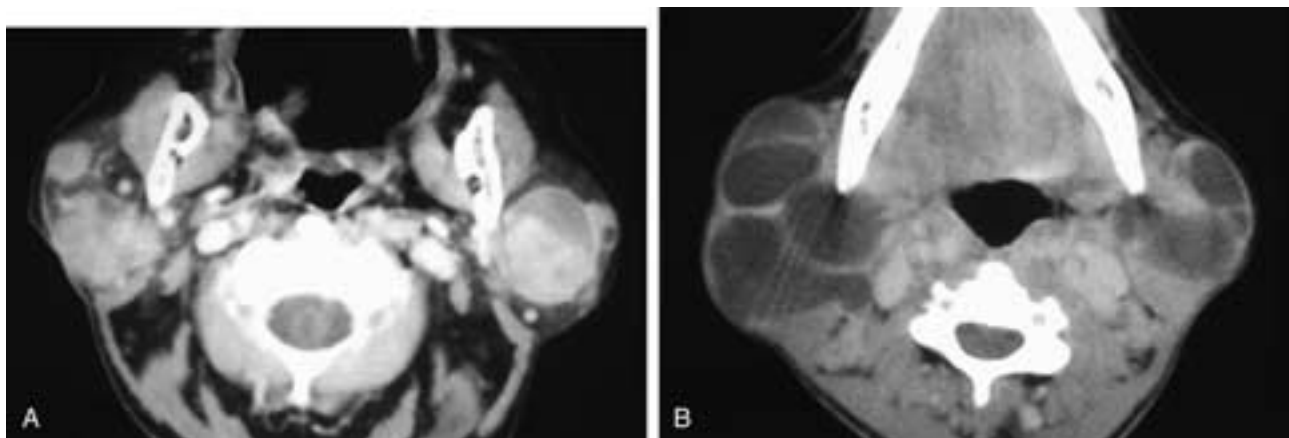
Axial contrast-enhanced CT scan (A) shows multiple bilateral parotid masses. The largest lesion on the left side is partially cystic. This patient had Warthin's tumors. In B, an axial contrast-enhanced CT scan shows multiple thinned-walled cysts in both parotid glands. No tumor nodules were seen in the cyst walls. This patient also had cervical adenopathy. These were lymphoepithelial cysts in an HIV-positive patient.
